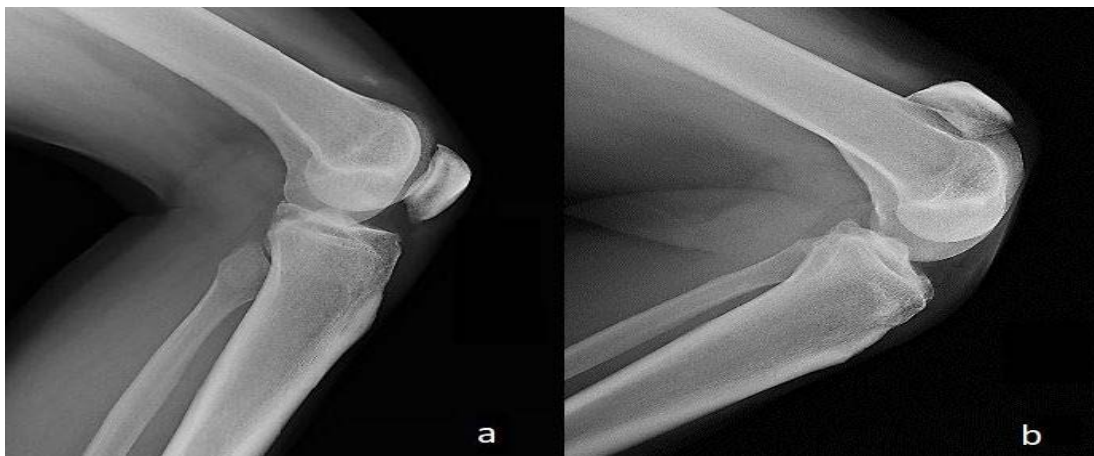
a. Preoperative lateral radiography of the right knee showing a patellae baja. b. Preoperative lateral radiography of the left knee showing a patellae alta.
